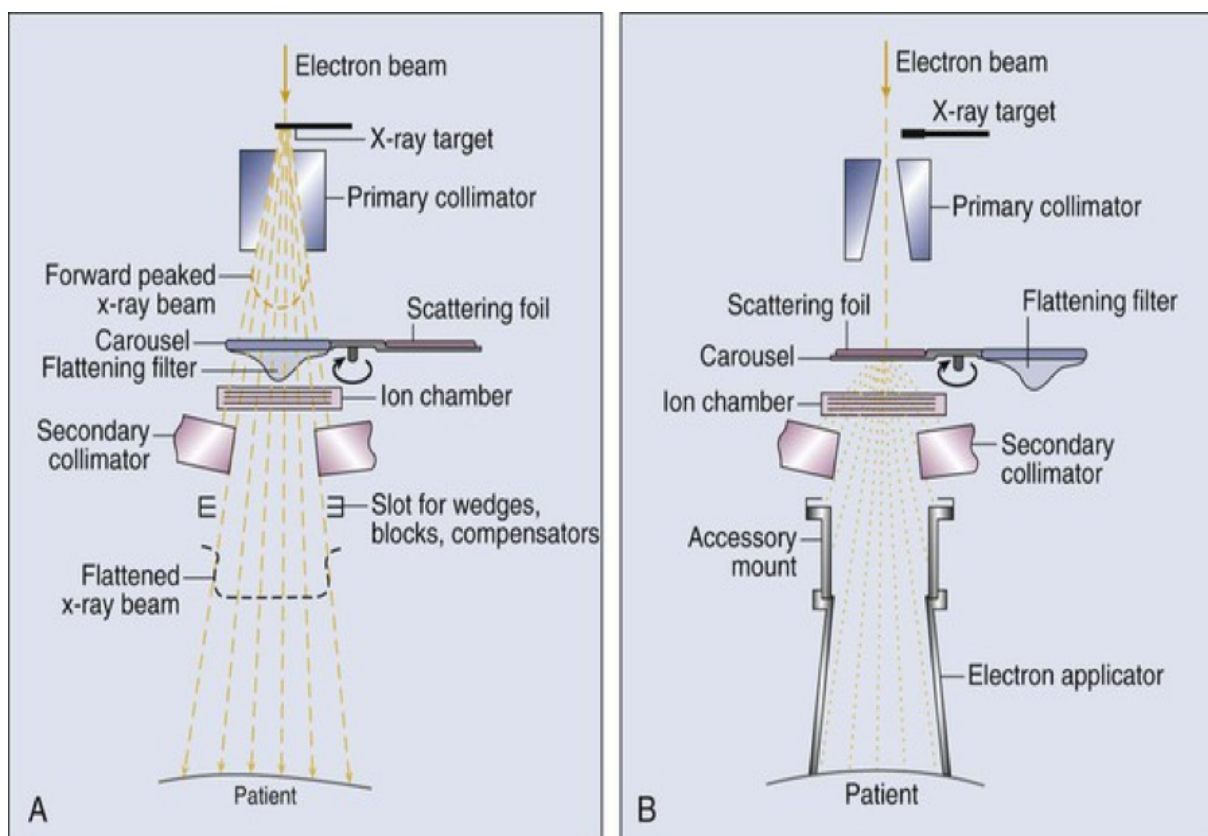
Components of treatment head A: X-ray therapy mode. B: Electron therapy mode.
